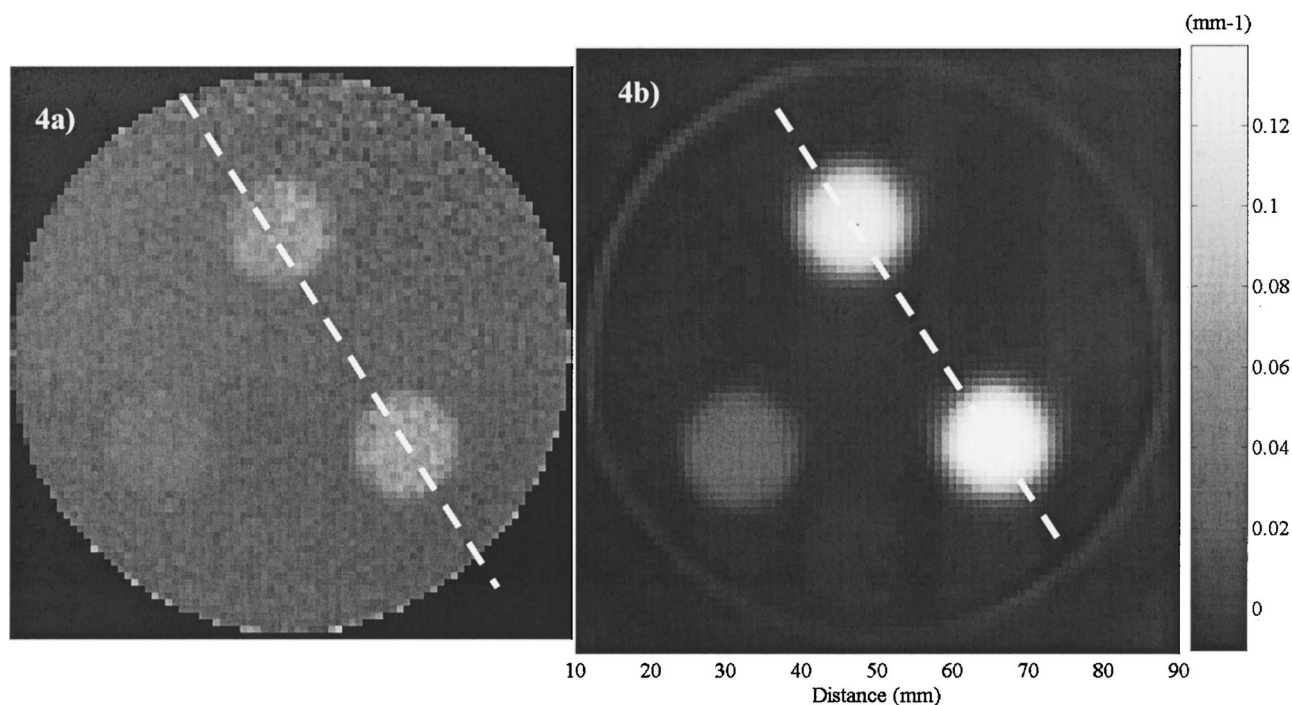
Unprocessed transaxial images through the same plane of the same calibration gel-flask (a) MR image of the R2 distribution, (b) optical-CT image of the change-in-optical-attenuation. The dotted line indicates the line profile of Fig. 5.
